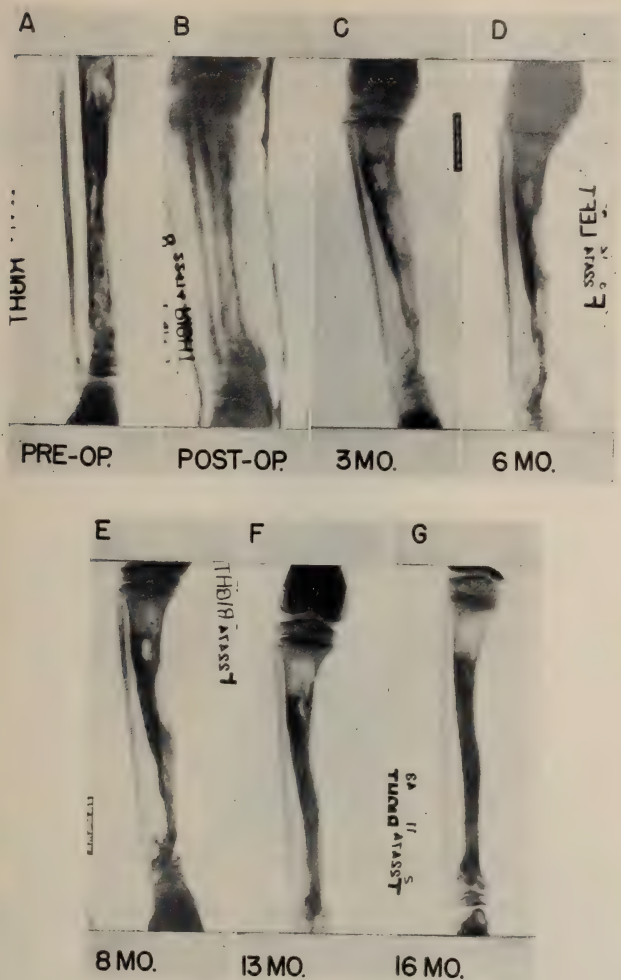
X-ray survey of progress of bone replacement.
